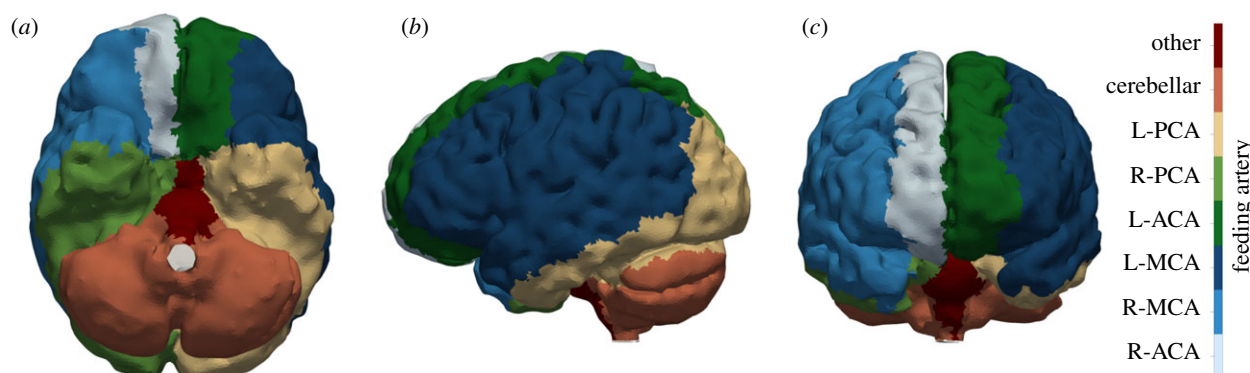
Superficial perfusion territories of large arteries projected onto the brain surface using the algorithm presented in [15,16] and VE-ASL MRI images [43]: (a) transverse view; (b) sagittal view; (c) coronal view. Territories corresponding to the left and right (L and R) hemispheres are labelled separately. Surface regions are coloured based on the feeding arteries using the following acronyms: anterior cerebral artery (ACA), middle cerebral artery (MCA), posterior cerebral artery (PCA).
